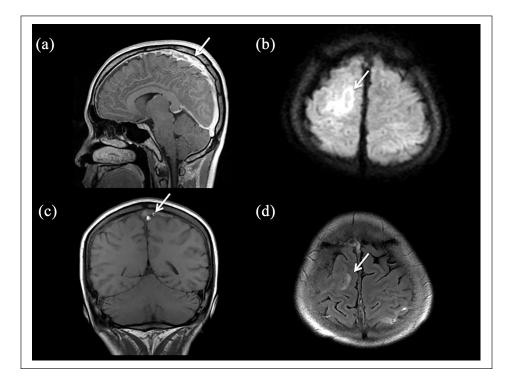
(a and b) Brain magnetic resonance imaging showed cerebral sinus venous thrombosis (arrows) in the superior sagittal sinus. (a) Gadolinium-ethoxybenzyl-diethylenetriamine penta-acetic acid (Gd-DTPA)-enhanced TI-weighted imaging and (b) diffusion-weighted imaging. (c and d) Brain magnetic resonance imaging performed at the end of the induction therapy showed a cerebral sinus venous thrombosis. The arrow indicates a residual lesion. (c) TI-weighted imaging and (d) fluid attenuated inversion recovery (FLAIR) imaging.
